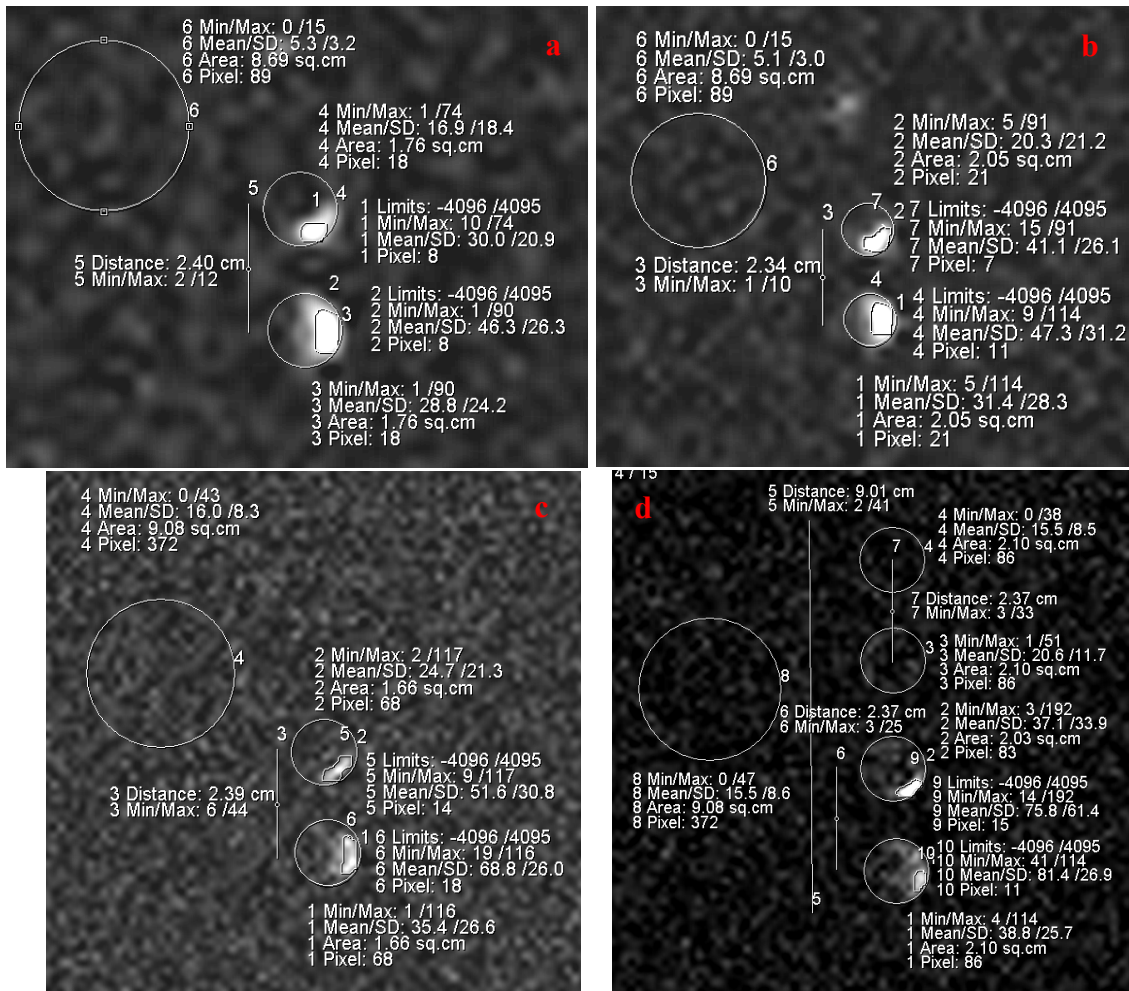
FLASH sequence of ^{19}F MRI used to compare TR and matrix size. a) TR of 10 ms and matrix size of 128x128. b) TR of 100 ms and matrix size of 128x128. c) TR of 10 ms and matrix size of 256x256. d) TR of 100 ms and matrix size of 256x256.
